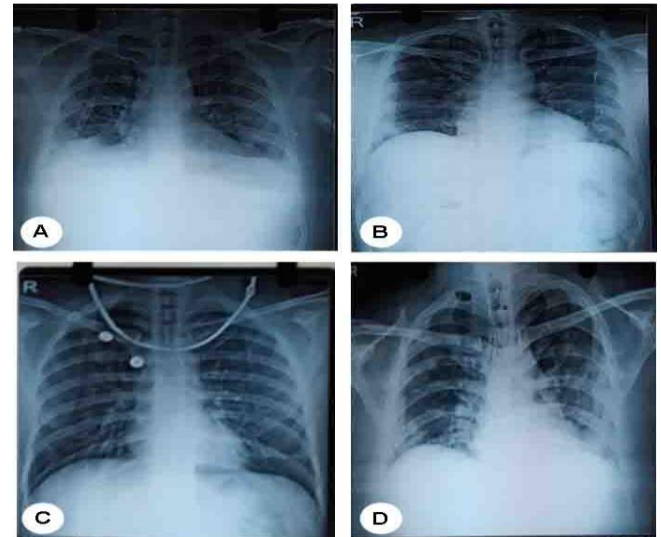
CHEST X-RAY OF STUDY PATIENTS SHOWING BILATERAL LUNG OPACITIES
